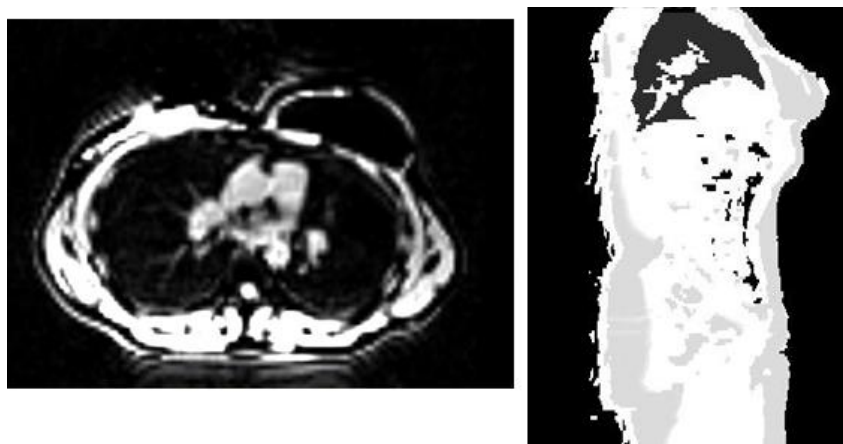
Shadowing artifacts were occasionally observed in the MRI image (left), producing signal outside the patient's body and misleading the segmentation of the body contour (right). The artifacts observed were likely related to patient motion.
